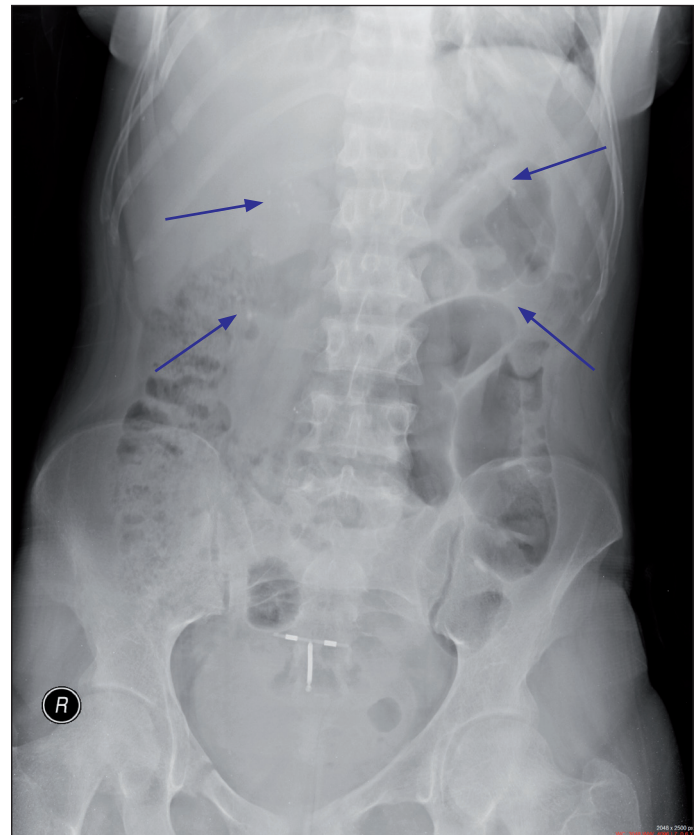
Plain radiograph of the patient demonstrating increased opacity in the kidneys.
